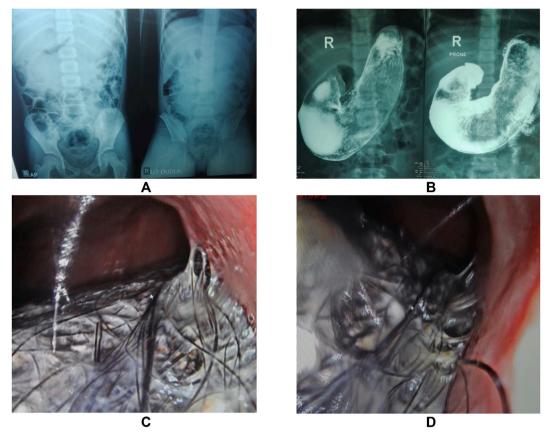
A) The plain abdominal x-ray showed radiopaque in the stomach. B) The upper GI x-ray, gastric intraluminal mass extended to the duodenal and impressed trichobezoar (Rapunzel syndrome). C) Upper site endoscopy showed trichobezoar. D) Lower site gastro-endoscopy after partially removed.
